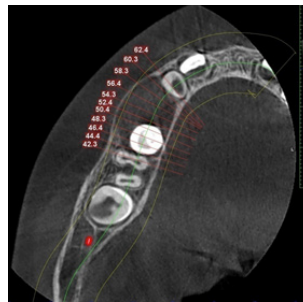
CBCT depicting minimum cortical bone expansion, thinning and erosion of the buccal cortical plates
